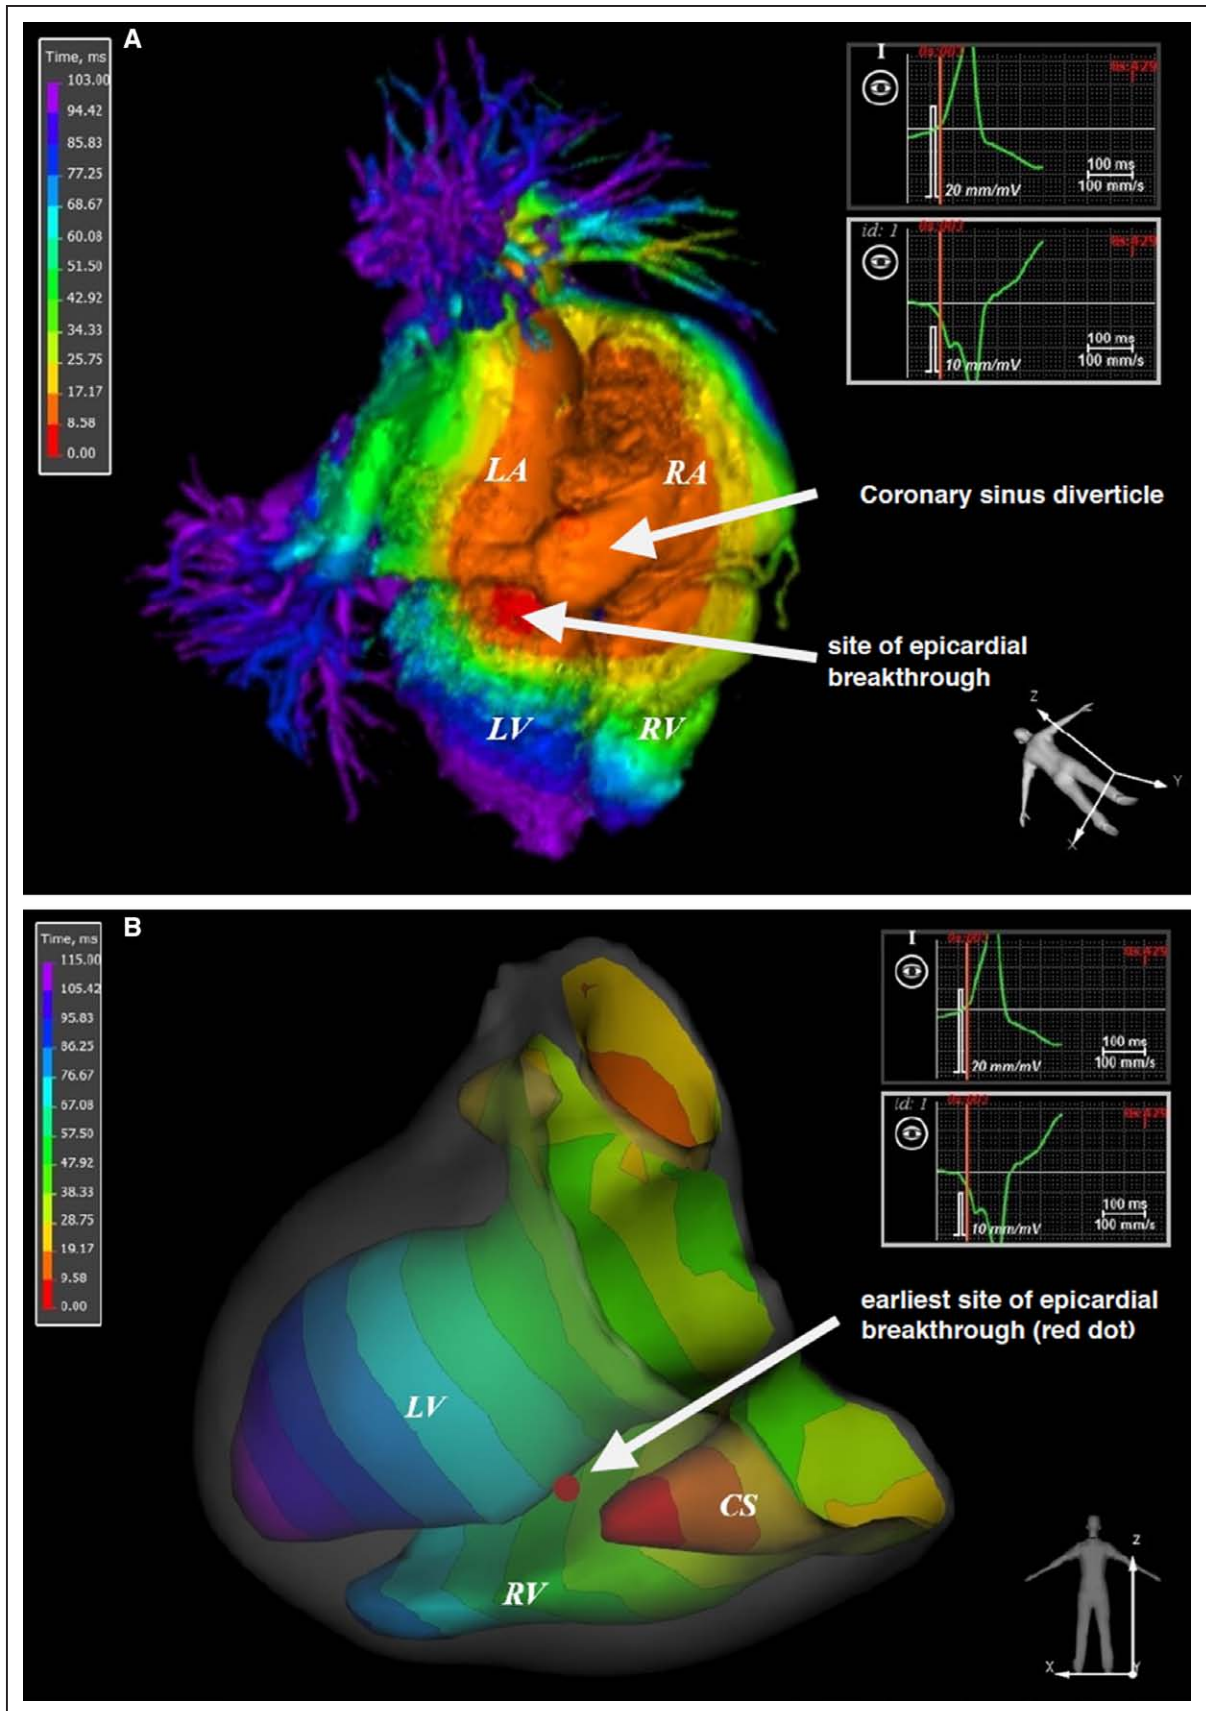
A, Isochronal epicardial map superposed on computed tomography 3-dimensional whole heart anatomy. B, Isochronal endocardial map depicted on the epi/endocardial ventricular model in the translucent epicardium mode. Coronary sinus (CS) diverticulum, ventricular tachycardia focus (red zone), and site of epicardial breakthrough posterobasal left ventricle (LV; red dot). (*Continued*)
